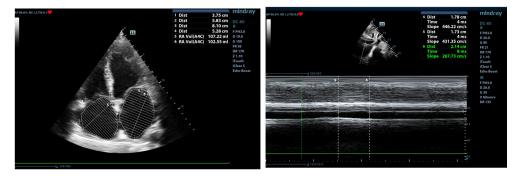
c.1. Biatrial dilation (left, 2D, apical 4-chambers view) and dilated IVC with reduced respiratory variability (right, M-mode, subxiphoid view)
